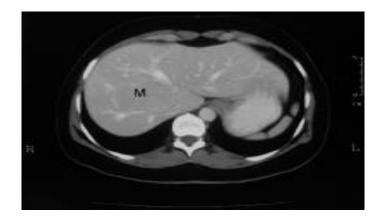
Delayed portal venous phase enhanced axial CT scan in a 38-year-old woman referred for gallbladder scan. Image shows stretching of the portal vein and the right hepatic vein around the mass (M).
